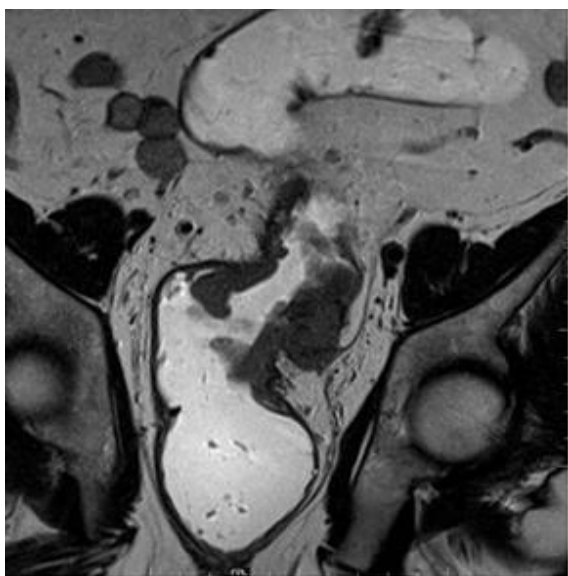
MRI T2W coronal images showing a circumferential morphology
